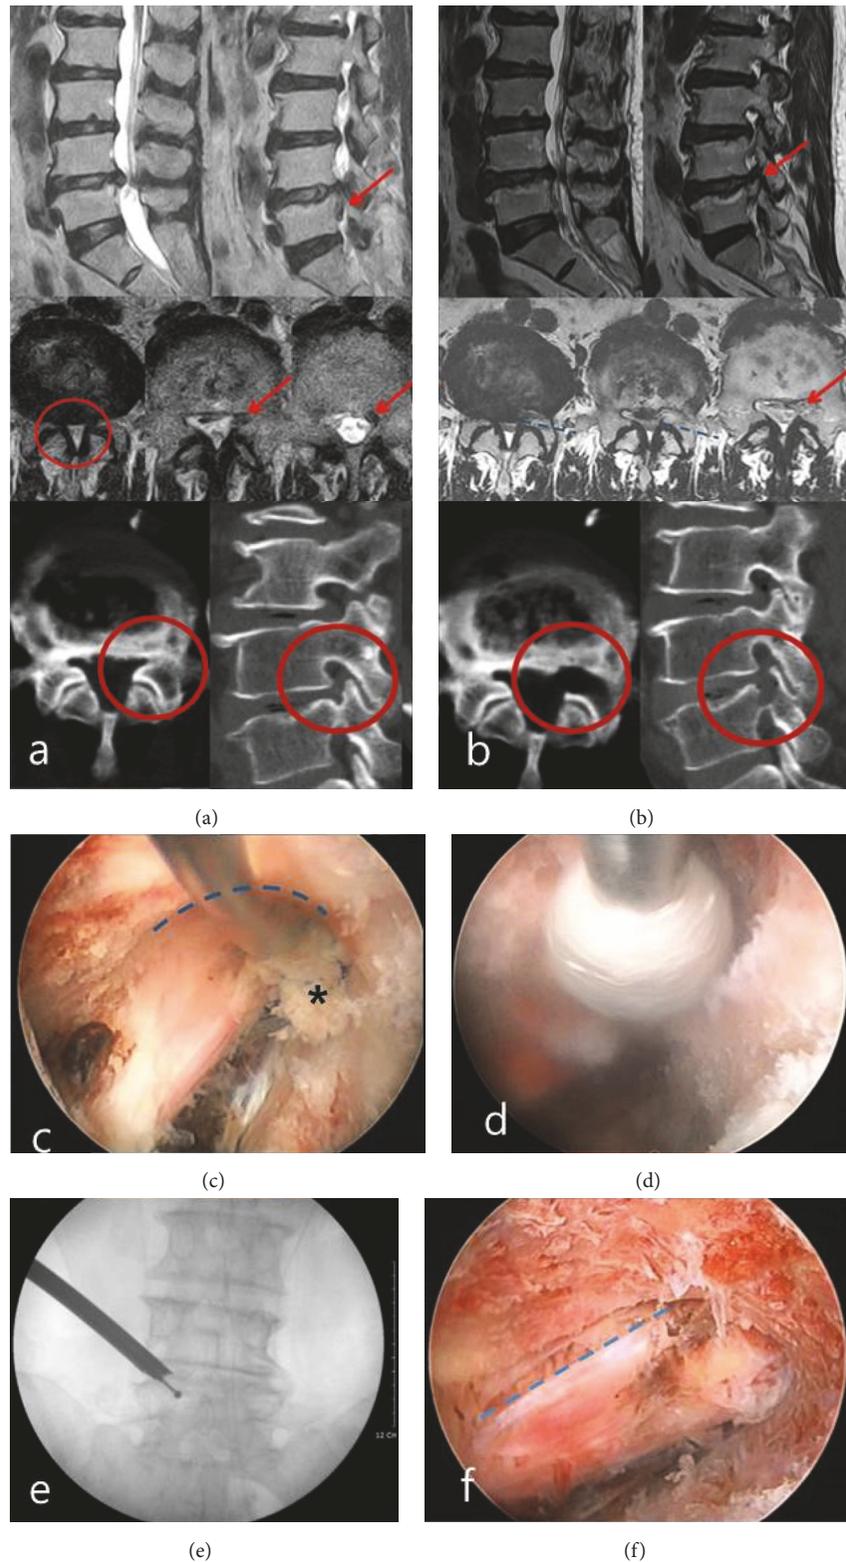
Highly inferior migrated disc combined with spinal canal and lateral recess stenosis. (a) Preoperative sagittal and axial T2-weight MRI showing ruptured right side inferior migrated disc material combined with central canal and lateral recess stenosis at L4-5. Red arrow: inferior migrated disc; red circle: stenotic region in spinal canal and lateral recess. (b) Postoperative axial and sagittal T2-weight MRI and CT showing the removed inferior migrated disc materials and decompression of lateral recess at L4-5. Red arrow: decompressed area by removal of inferior migrated disc materials; red circle: decompressed area from preoperative stenosis; blue dotted line: resected plane of superior articular process. (c) Part of inferior migrated disc materials was seen by retraction of flexible probe. Dotted blue line: resected ventral plane of superior articular process by reamers; asterisk: tip of inferior migrated disc materials. (d) Further decompression of lateral recess was performed by drilling. (e) Intraoperative C-Arm image showing the location of drill tip during lateral recess decompression. (f) Totally decompressed traversing root was seen at the end stage of operation blue dotted line: dorsal margin of the traversing root.
